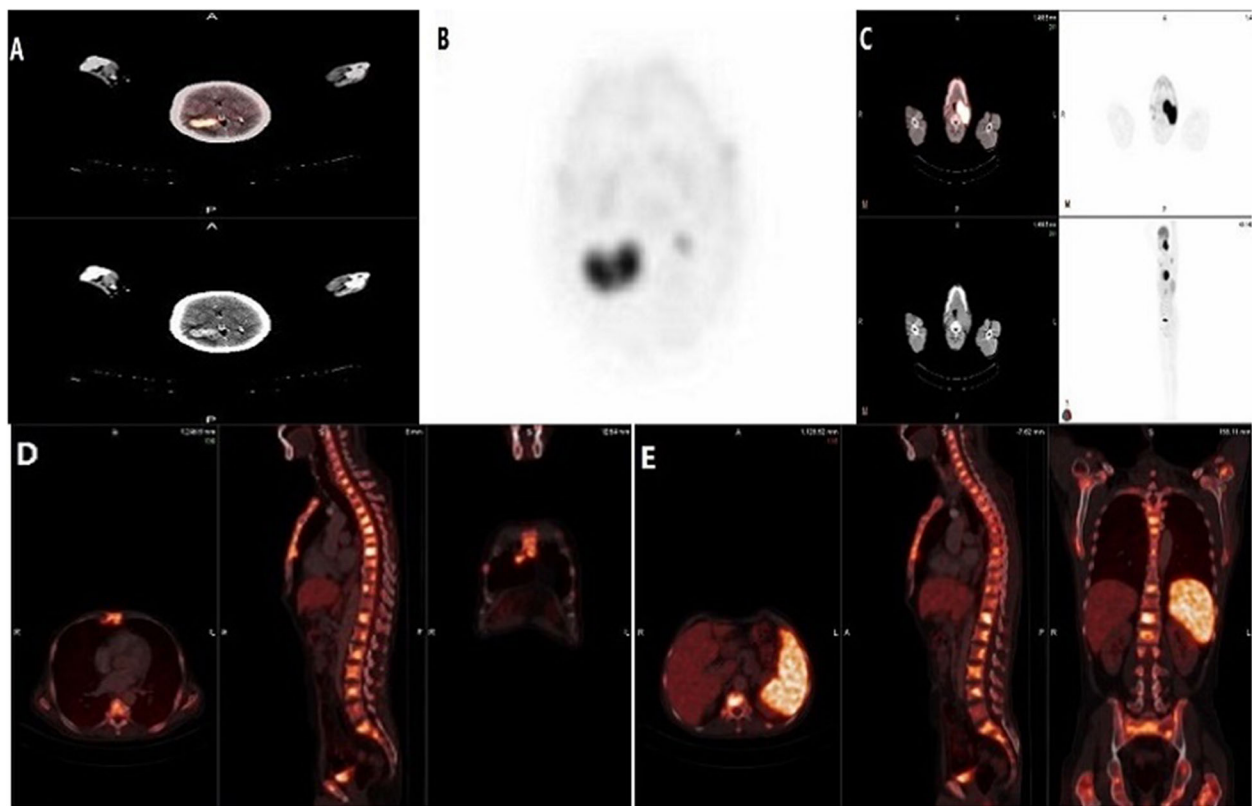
A 58-year-old male with two metastatic mass lesions in the right parietal lobe. a, b Axial fused PET/CT and multiplanar PET scan showed two metastatic lesions in the right parietal lobe with active FDG uptake. c Axial fused PET/CT and CT scan showed an active mass in the left nasopharynx proved by nasopharyngoscopic biopsy to be nasopharyngeal carcinoma. d, e Multiplanar fused PET/CT scan showed cervical, dorsal, and lumbar vertebral bodies with increased metabolic activity indicating metastatic lesions; also, metastasis were seen in the spleen and in the sternum
